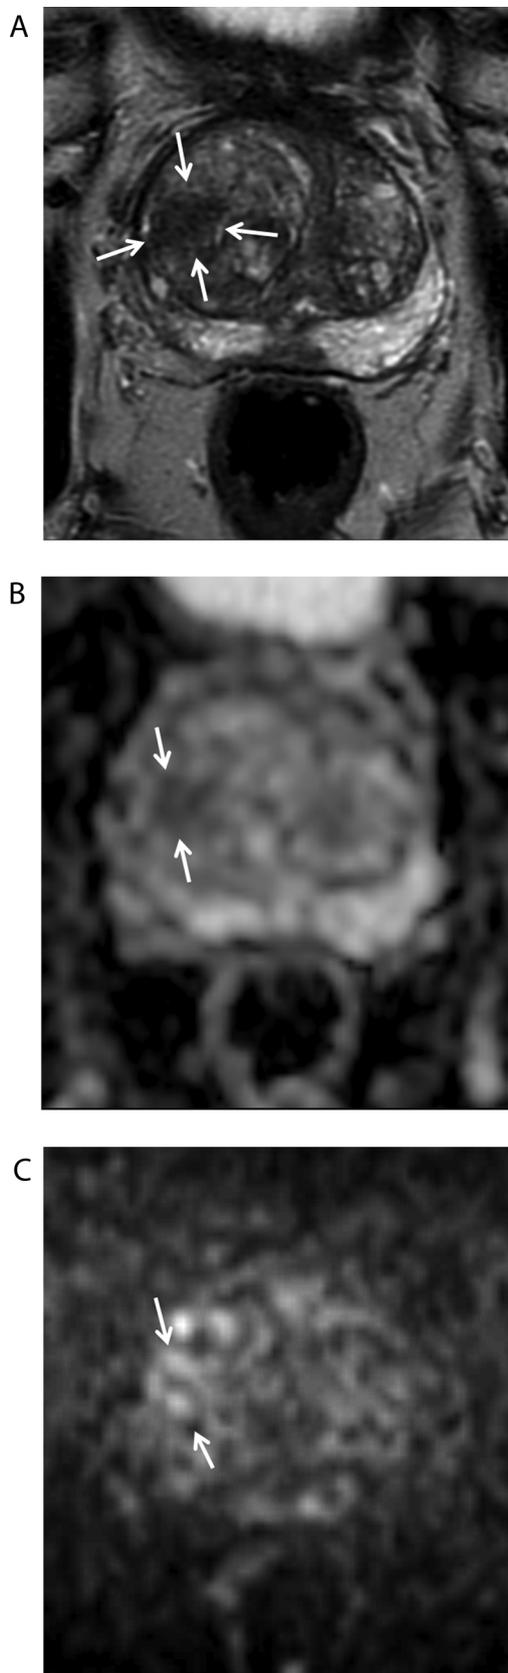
A 78-year-old man with suspected prostate cancer (prostate-specific antigen level, 7.18 ng/mL) in the right transition zone. MRI-transrectal ultrasonography fusion-guided prostate-targeted biopsy confirmed a diagnosis of benign prostatic condition with hyperplasia and atrophic glands. a: T2-weighted image shows an area of heterogeneous hypointensity with obscured margins, including some that do not qualify as score 2, 4, or 5, in the middle lateral region of the transition zone in PI-RADS v2, and a mostly encapsulated nodule in PI-RADS v2.1 (arrows). b: Apparent diffusion coefficient (ADC) map shows indistinct mild hypointensity (arrows). c: Diffusion-weighted image shows indistinct mild hyperintensity (arrows). According to the PI-RADS v2 decision rules, the lesion was assigned a T2-weighted imaging score of 3, a DWI/ADC map score of 2, and the overall PI-RADS category was 3 for both readers. For both readers, the lesion was assigned a T2-weighted imaging score of 2, a DWI/ADC map score of 2 (including some that do not qualify as 3, 4, or 5), and an overall category of 2 according to the PI-RADS v2.1 decision rules. Thus, compared with PI-RADS v2, PI-RADS v2.1 improved the diagnostic performance for transition zone prostate cancer detection in both readers.
